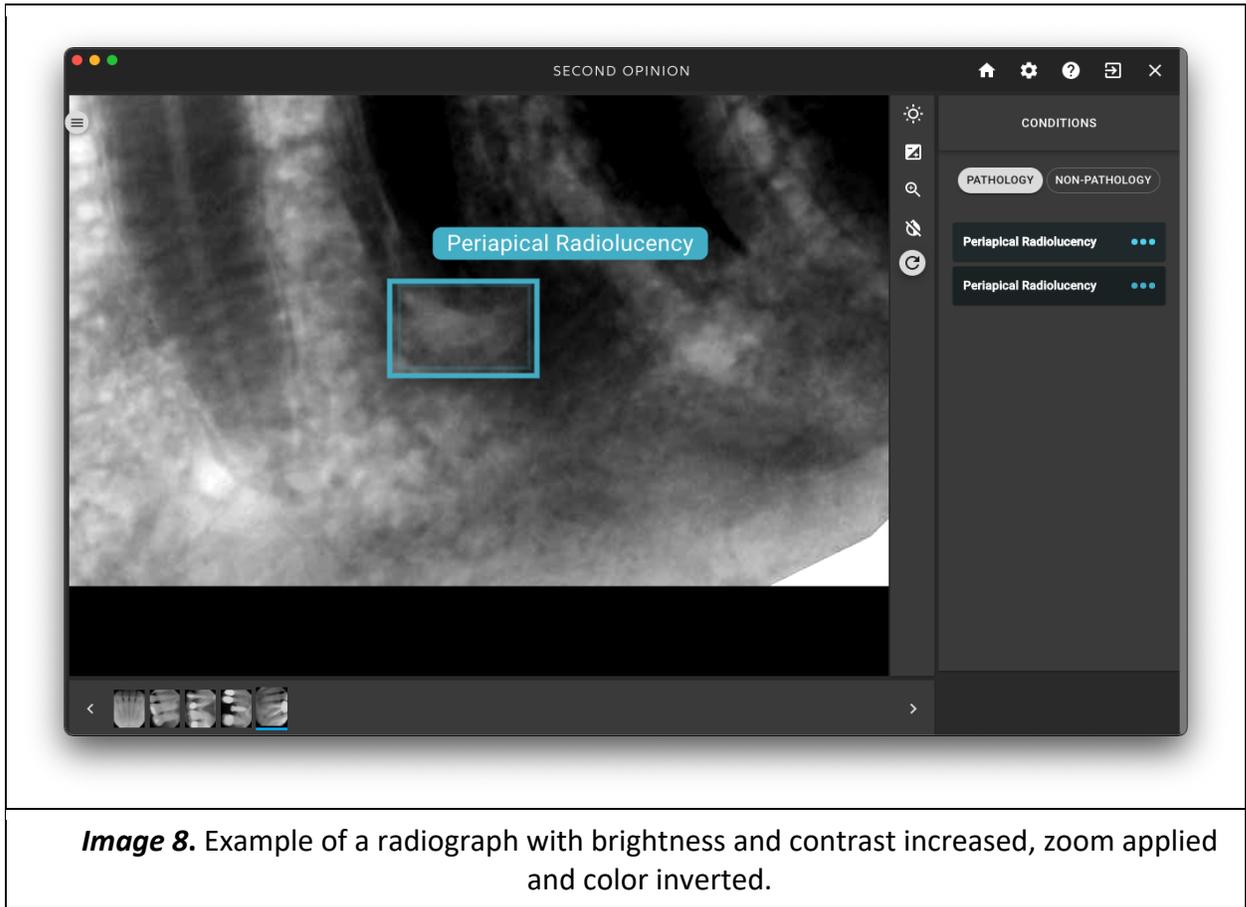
Example of a radiograph with brightness and contrast increased, zoom applied and color inverted.
